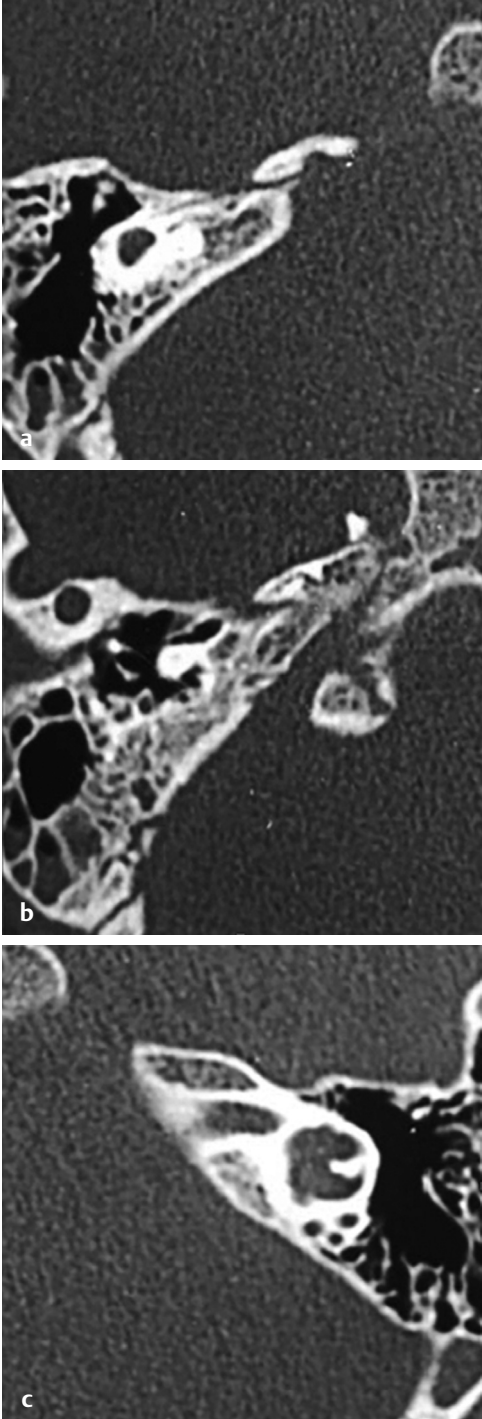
HRCT temporal bone, bone window, axial sections show CVM type IV, (a) rudimentary otocyst without IAC, (b) CLA, and (c) cochlear aplasia.
